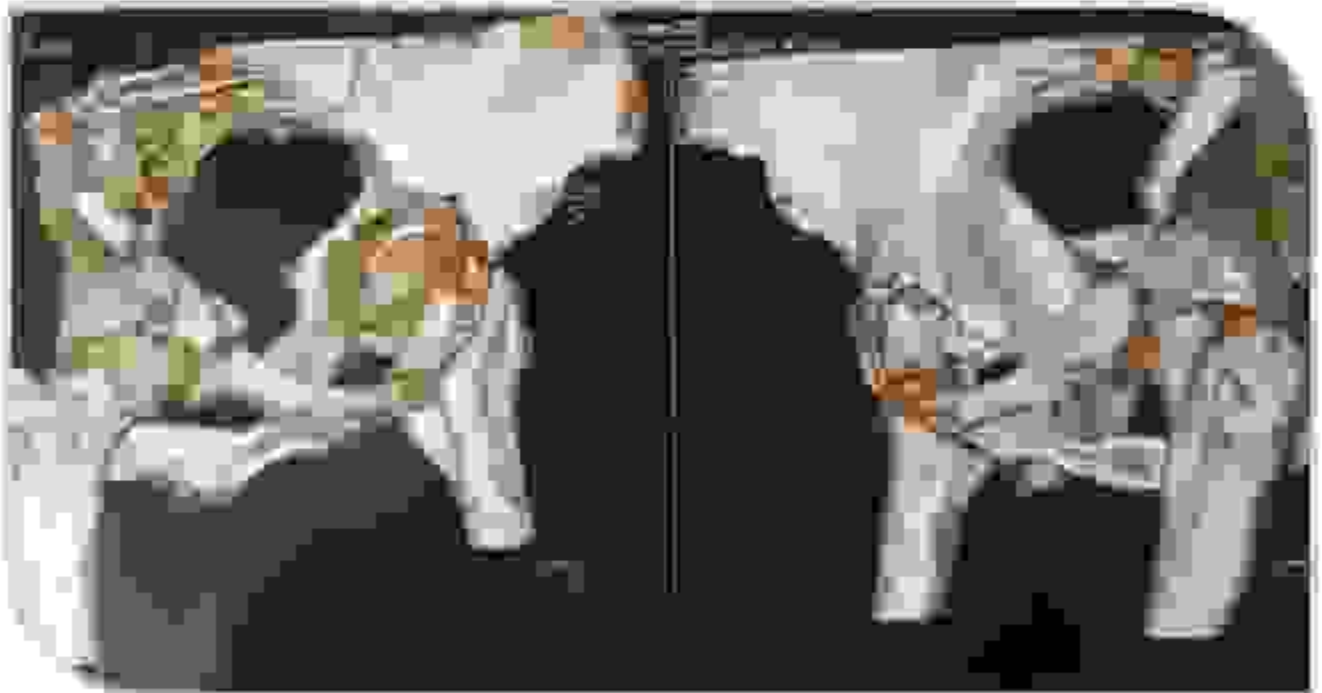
3D CT image (Judelet View).
